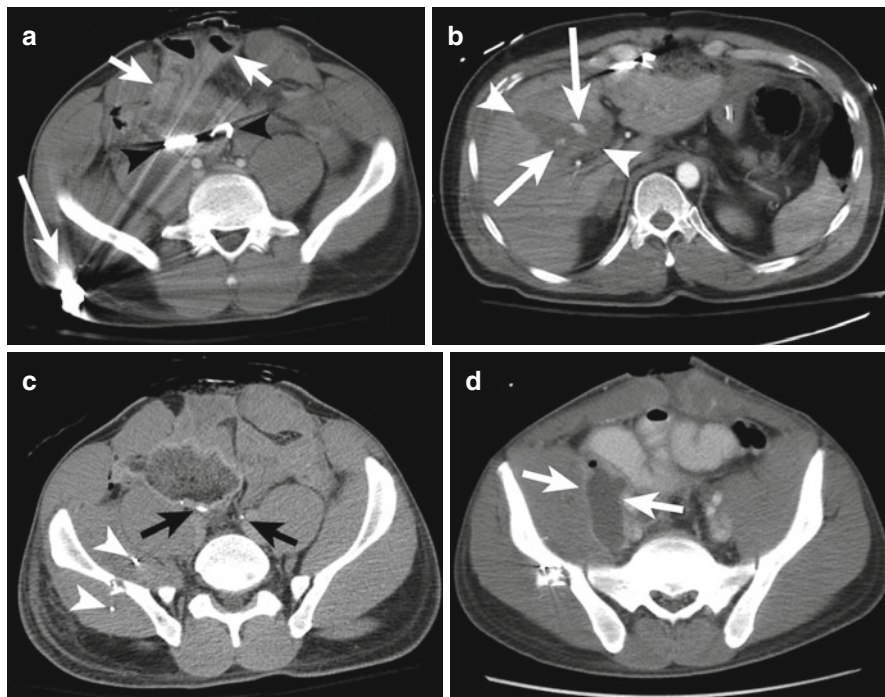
A 26 year-old male presented to the trauma service after sustaining a gunshot wound to the abdomen. The patient underwent bowel resection and laser coagulation of liver lacerations. (a) Post-operative computed tomography (CT) shows the bullet fragment (*long white arrow*) in the right gluteal musculature, laparotomy pads (*black arrowheads*) at the root of the mesentery and thickened, clumped small bowel (*short white arrows*). (b) More superiorly, there is active hemorrhage (*arrows*) within a hepatic laceration (*arrowheads*). (c) Delayed phase image shows contrast within the normal ureters (*black arrows*) and shrapnel (*arrowheads*) adjacent to the fractured right iliac bone. (d) One week later, an abscess (*white arrows*) has developed
